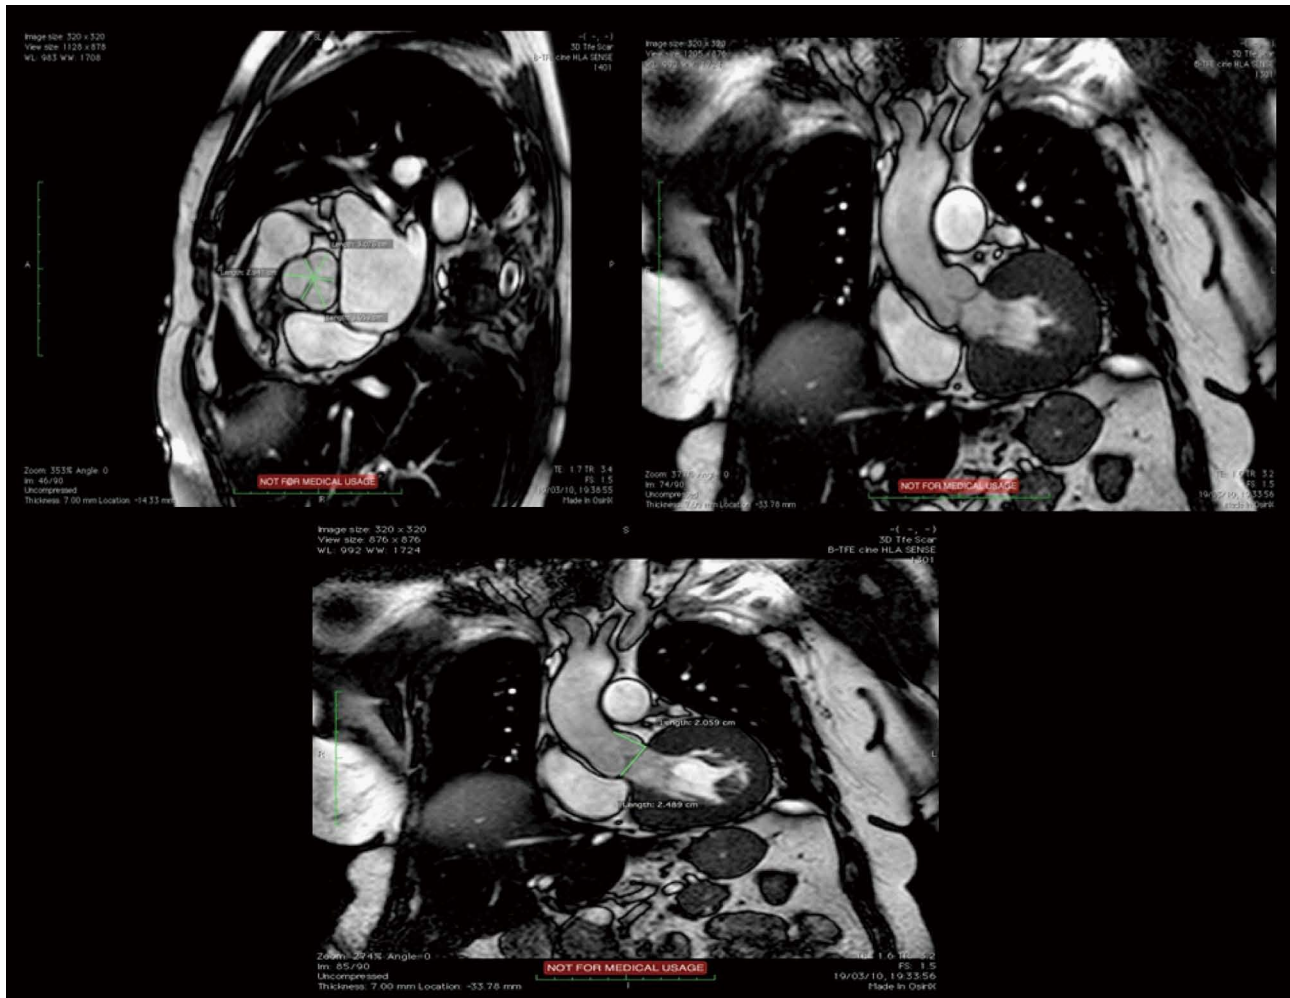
Balanced fast-field echo unenhanced magnetic resonance images showing the normal tricuspid aortic valve, with the typical “Mercedes-Benz Sign” and the first tract of the ascending aorta.
